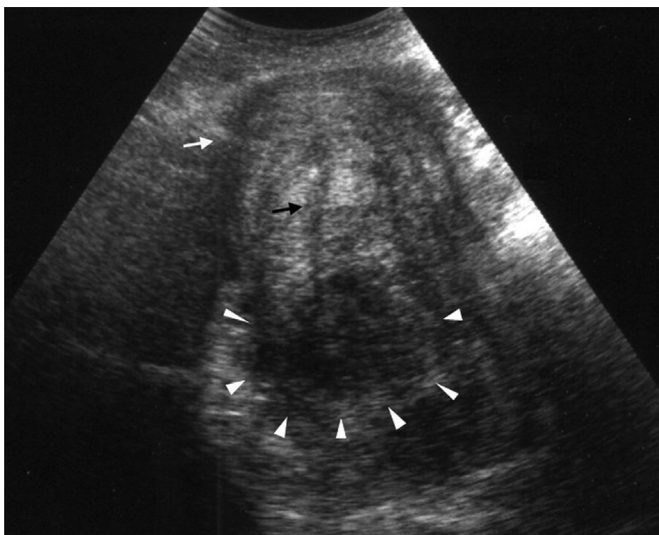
The longitudinal ultrasound scan showed an indentation (white arrow) and a longitudinal hypoechoic groove (black arrow) at the uterine fundus, which provided the diagnosis of uterine inversion. The arrowheads outline the protruding mass.
